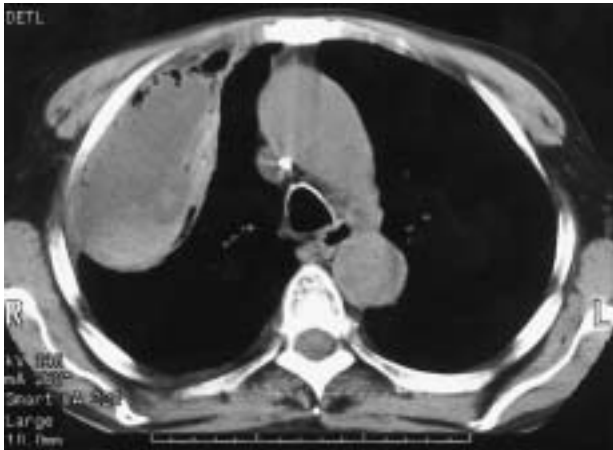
Thoracic computed tomography scan performed 8 days after catheterization.
